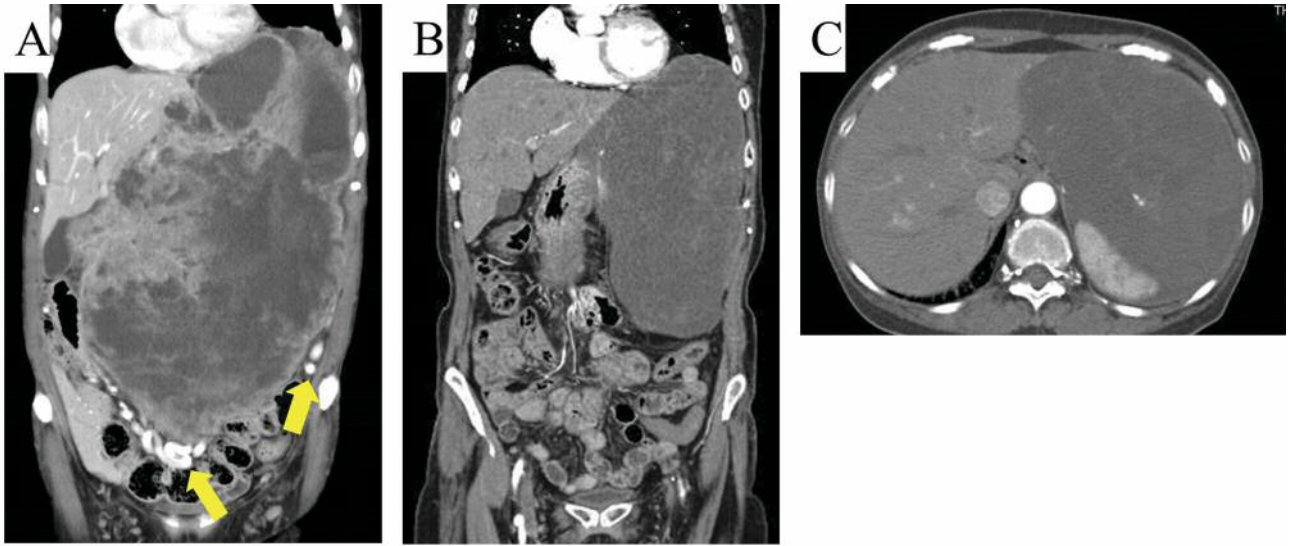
Abdominal computed tomographic images before (A) and after (B and C) neoadjuvant treatment with imatinib mesylate (IM). A: A large heterogeneous mass was detected extending from the top of the left diaphragm into the pelvic cavity, with dilated vessels around the tumor (arrows). B, C: Thirteen months after the initiation of IM therapy, tumor size was reduced, and the dilated vessels had disappeared (B). Adhesion between the tumor and spleen was suspected (C).
